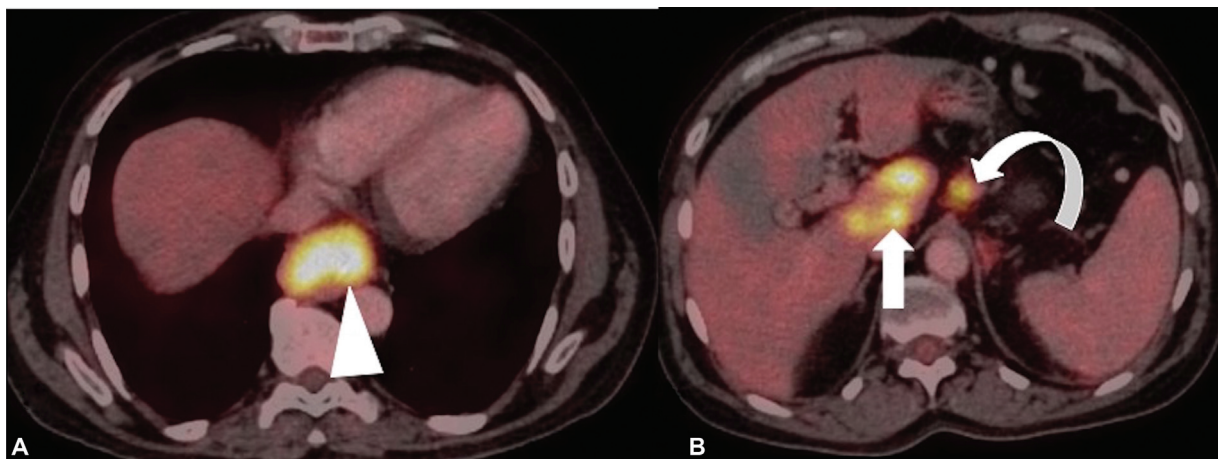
(A and B) Staging of esophageal cancer on fluorodeoxyglucose-positron emission tomography/computed tomography (FDG-PET/CT) images reveals moderately FDG-avid primary esophageal mass lesion (arrowhead) with extensive FDG-avid metastatic abdominal nodes (curved arrow) and multifocal hypermetabolic hepatic (metastatic) lesions (arrow) implying M1 stage.
